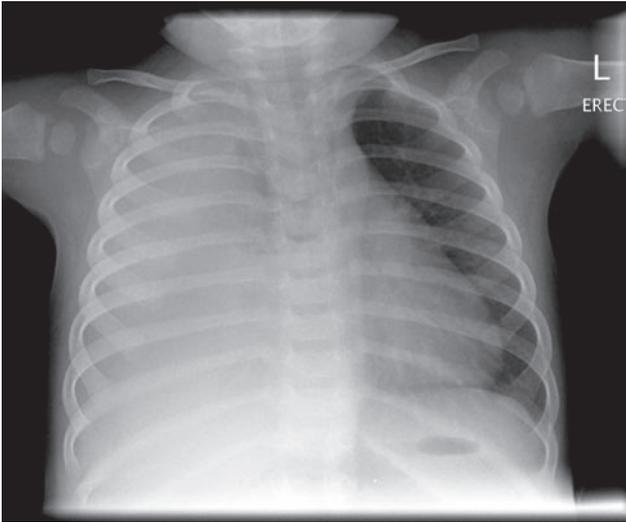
Chest X-ray showing a complete "white out" of the right side.
